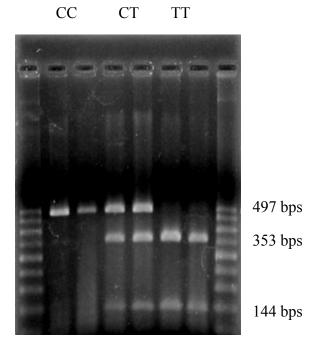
PCR-RFLP analysis for CD14/-159 genotypes. Extracted genomic DNAs were subjected to PCR amplification specific for a CD14 region followed by a AvaII digestion and then electrophoresis on an agarose gel. The presence of a band (497 bps), 3 bands (497, 353, and 144 bps), and 2 bands (353 and 144 bps) indicated homozygous CC, heterozygous CT and homozygous TT, respectively.
